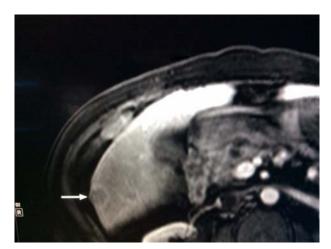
Contrast-enhanced MRI demonstrating segment VI lesion in the second OLT (white arrows).
